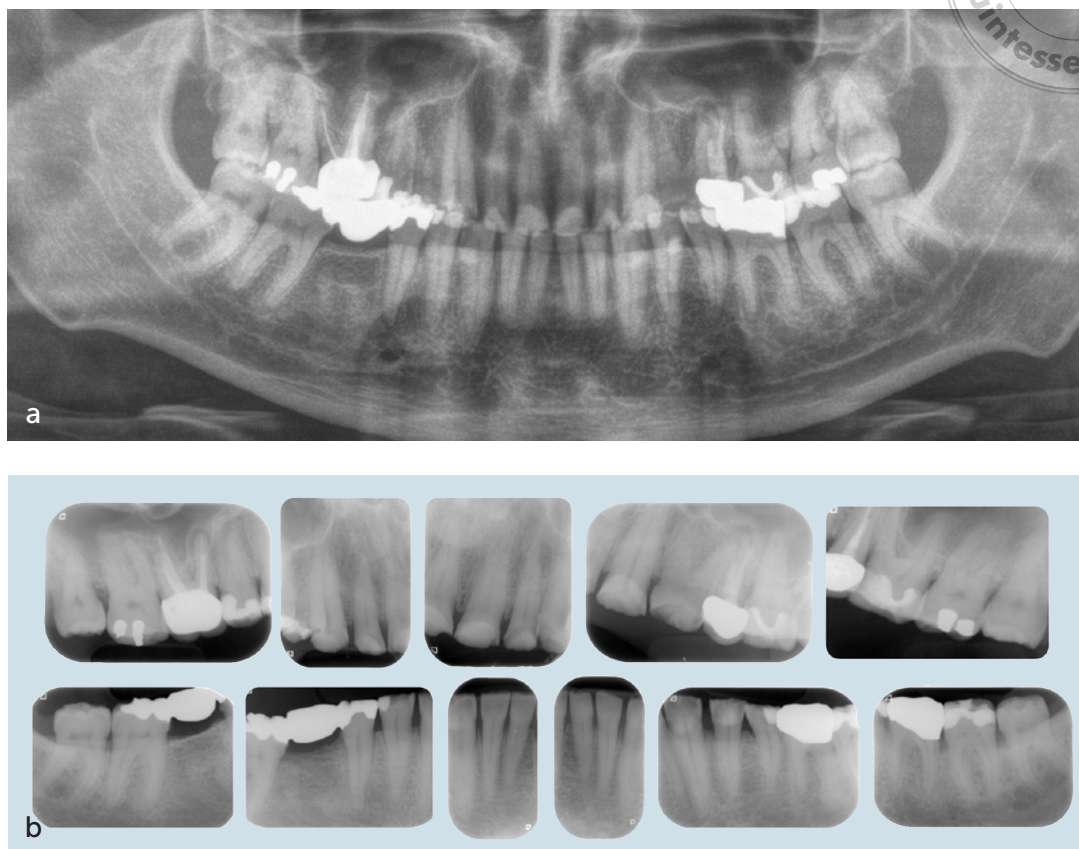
The radiographic assessment revealed insufficient root canal therapy on teeth 16 and 25 as well as a periapical lesion on tooth 16.
